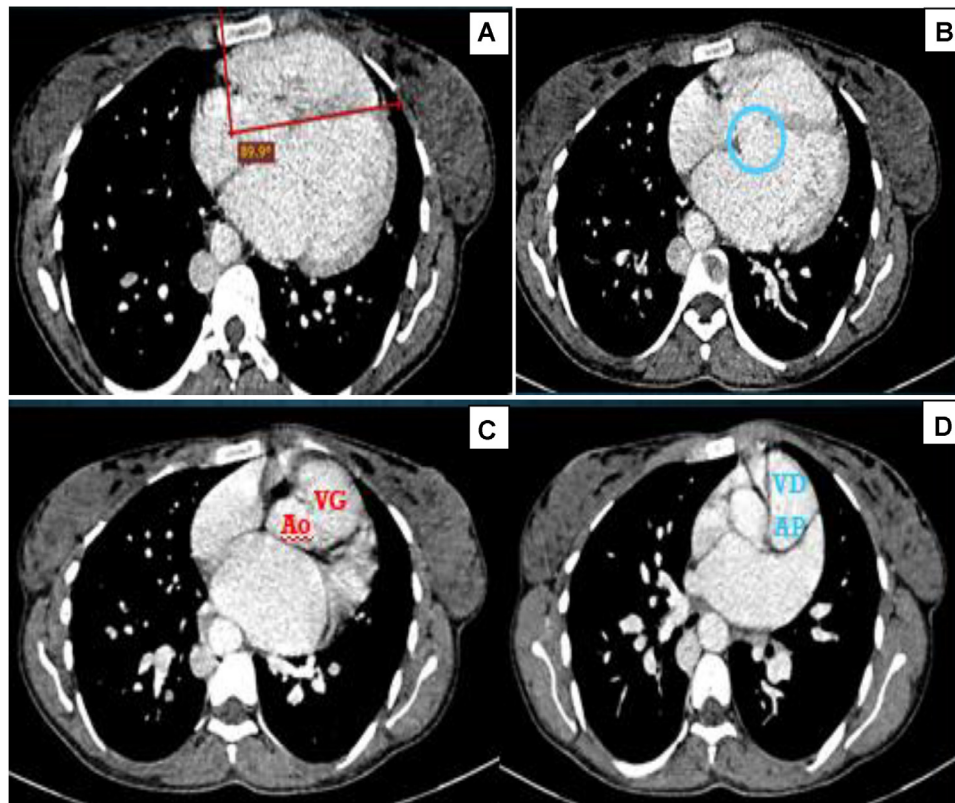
The injected thoracic CT scan of our patient revealed extreme levocardia, indicated by a deviation of the interventricular septum axis to the left of more than 65° (A), and an interventricular septal defect (B). Additionally, there was atrioventricular and ventriculoarterial concordance, indicating a normal arrangement of the major vessels (C, D).
